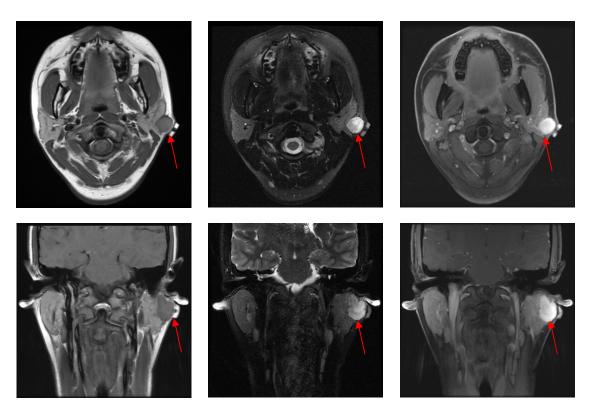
MRI revealed a well circumscribed heterogeneous and enhancing 2 cm x 3 cm mass in the left infra-auricular region, superficial to the left parotid gland with prominent cervical adenopathy. Impression was that findings were consistent with an inflamed first branchial cleft cyst
